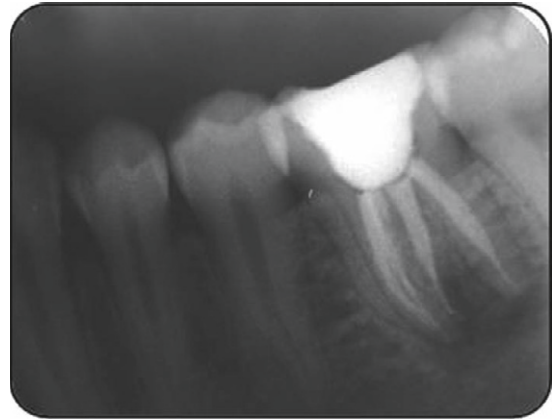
Post-obturation radiograph of mandibular left first molar.
